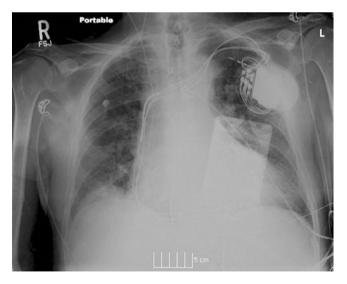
X-ray displaying correct position of pacing wire in the right ventricle
